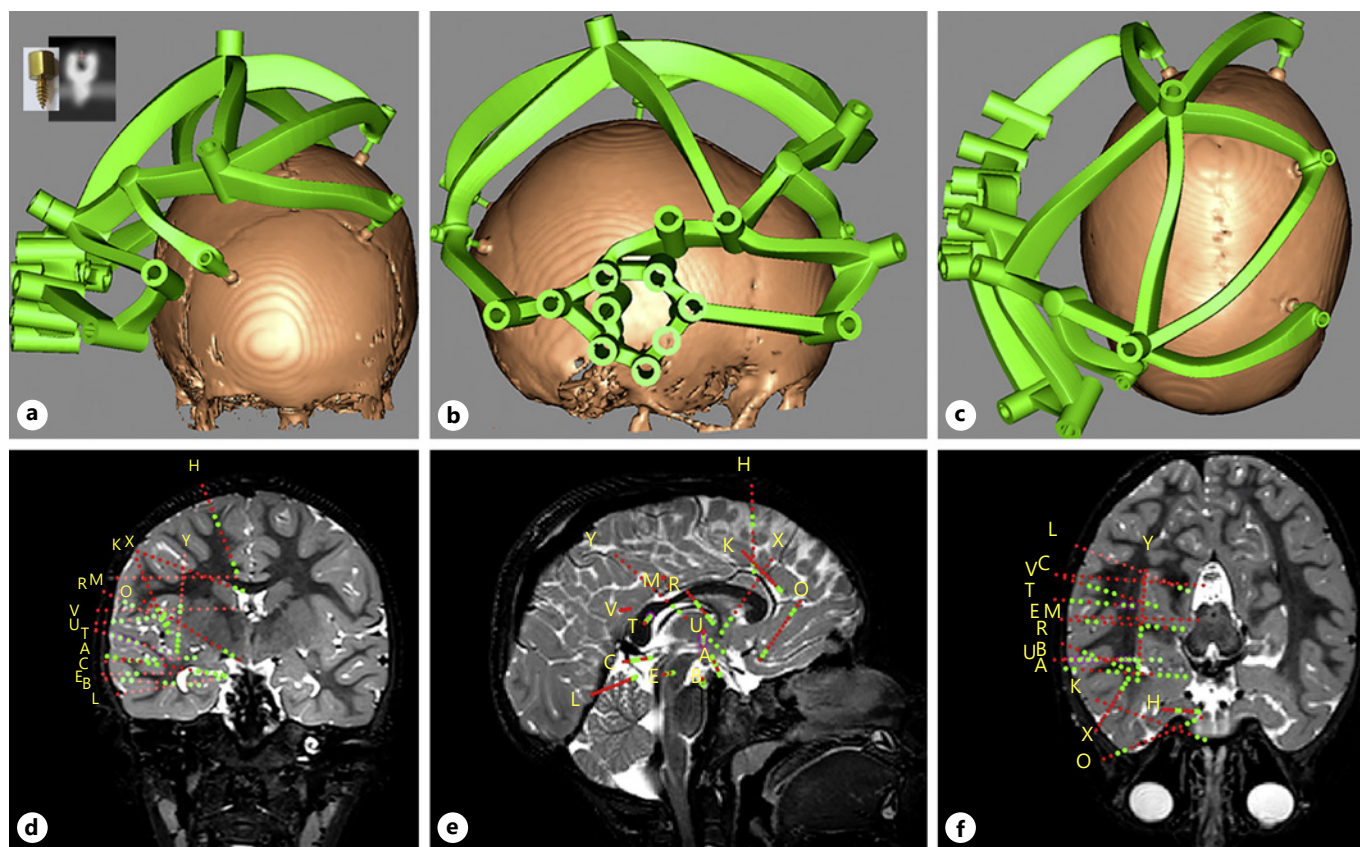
a–c Different views of the personalized stereotactic fixture used for implanting depth electrodes in the pediatric patient. The inset in panel a shows a 5-mm anchor and its appearance on the preimplantation CT. d–f Electrode localization, superimposed on patient's MRI. The contacts included in the recording montage ($n = 64$) are shown in green, while the remaining ones ($n = 131$) are shown in red.
